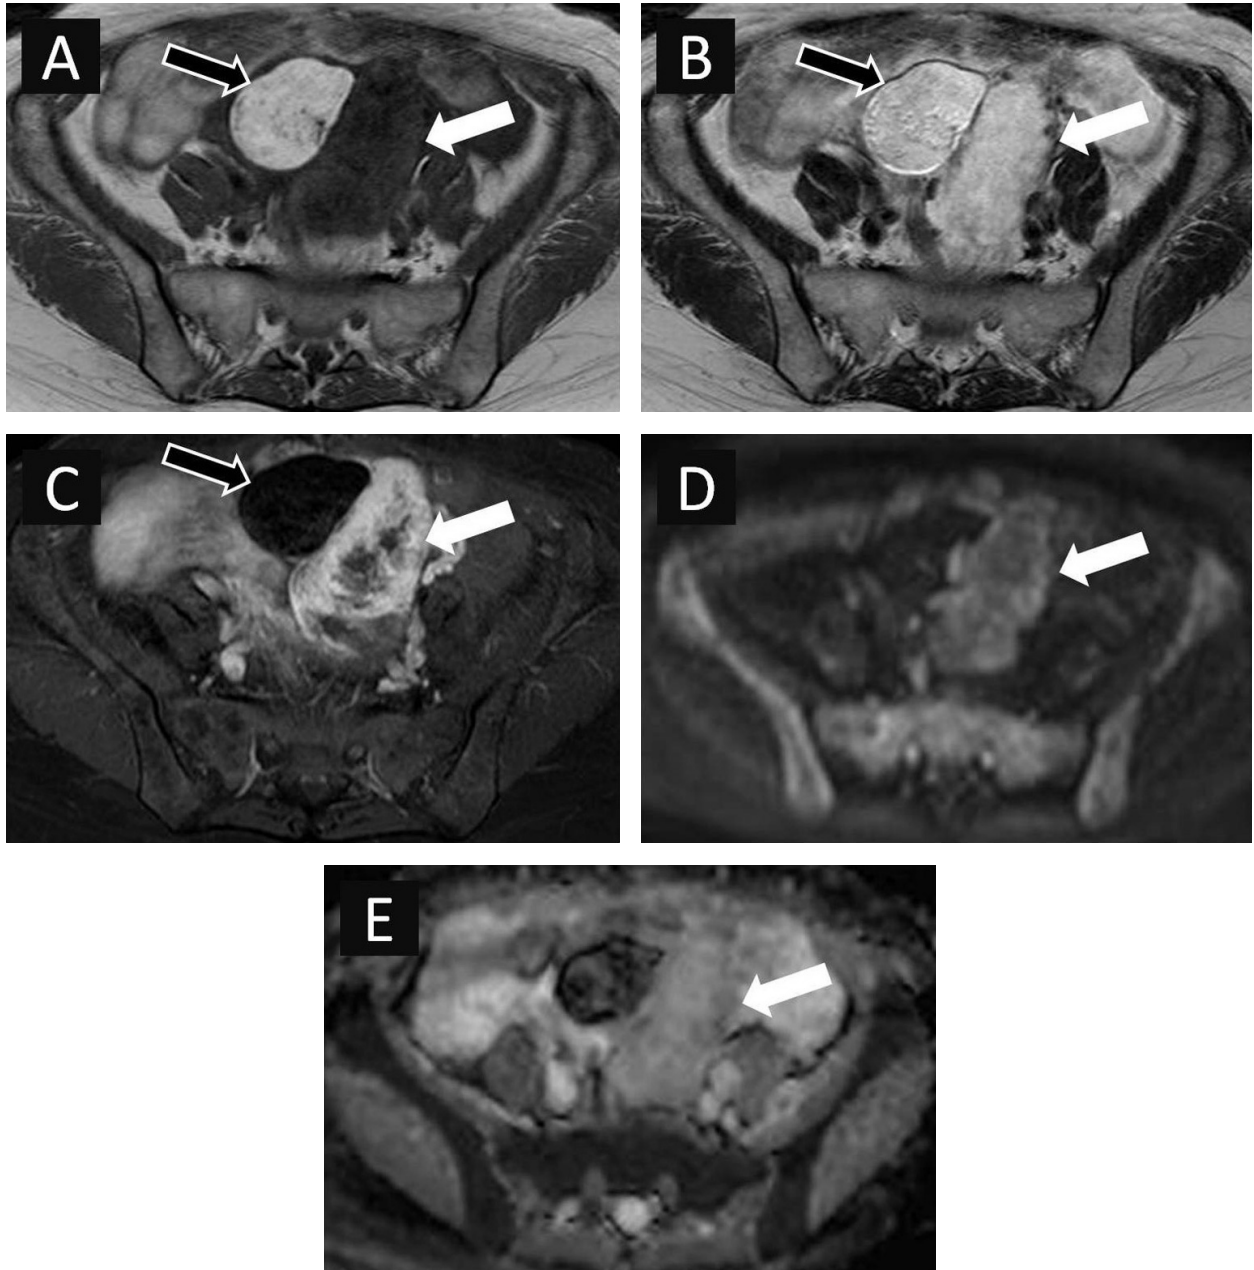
A, On this axial T1-weighted spin-echo MR image, the lateral part of the tumor shows low signal intensity (white arrow). Note that the medial part of the tumor shows high signal intensity (black arrow). B, On this axial T2-weighted fast spin-echo MR image at the same level as in Figure 1A, the lateral part of the tumor shows heterogeneous, high signal intensity (white arrow). Note that the medial part of the tumor shows high signal intensity (black arrow). C, On this axial contrast-enhanced fat-suppressed T1-weighted fast spin-echo MR image at the same level as in Figures 1A and 1B, the lateral part of the tumor shows intense enhancement (white arrow), suggesting a solid appearance with a hypervascular nature. Note that the medial part of the tumor shows signal loss, indicating the presence of macroscopic fat within the lesion (black arrow). D, On this axial diffusion-weighted MR image ($b=1000$ second/ mm^2) at the same level as in Figures 1A, 1B, and 1C, the lateral part of the tumor shows slightly high signal intensity (white arrow). E, The corresponding apparent diffusion coefficient (ADC) map image at the same level as in Figure 1D. On this axial ADC map image, the lateral part of the tumor shows high signal intensity (white arrow). The calculated ADC value of the lateral part of the tumor is $2.45 \times 10^{-3} \text{ mm}^2/\text{s}$.
